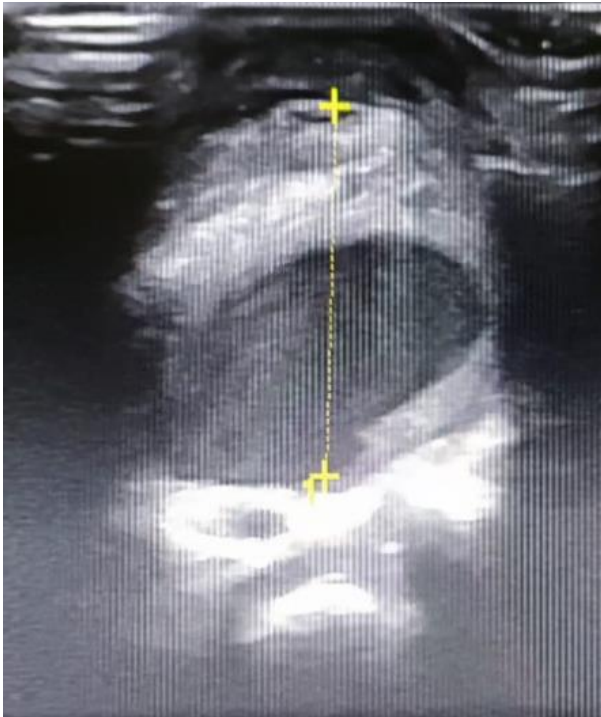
Ultrasound of the mass: rounded formation, seat of turbulence, with thickening of its wall testifying to its partial thrombosis
